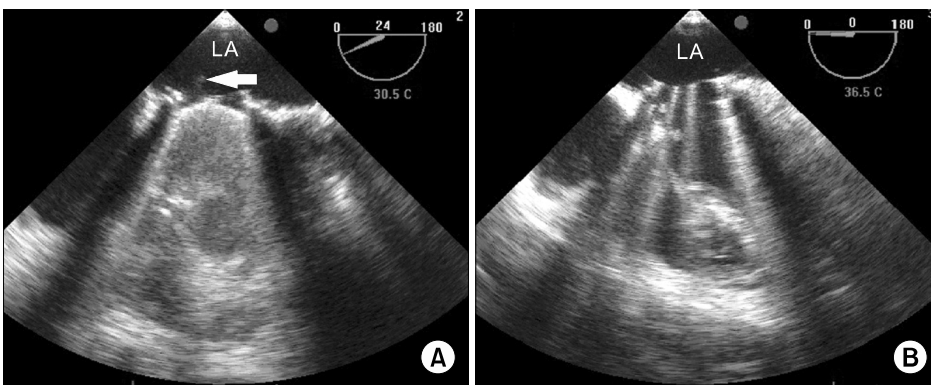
Transesophageal echocardiography shows (A) a mass on the prosthetic valve, (B) regression of the mass. Arrow shows mass on the prosthetic valve. LA, left atrium.
